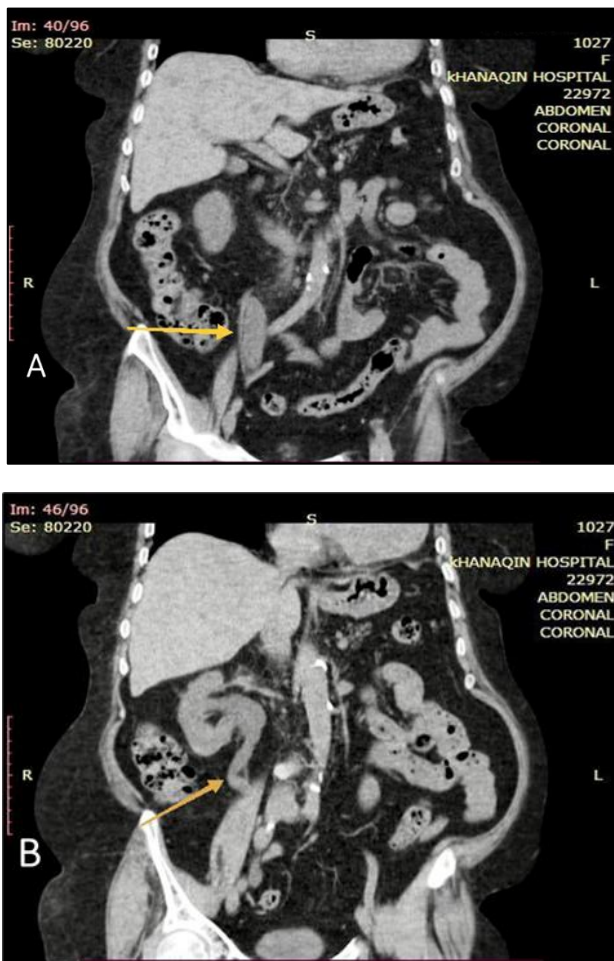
A, B where native abdominal CT scan shows dilated upper ureter (A) middle and lower ureter (B).
